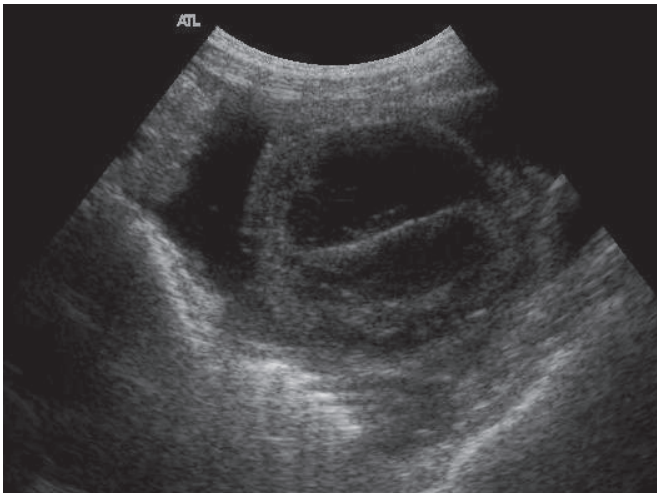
The ultrasound examination performed four days after the onset of symptoms shows evolution of the lesion with a slight decrease in its size.
